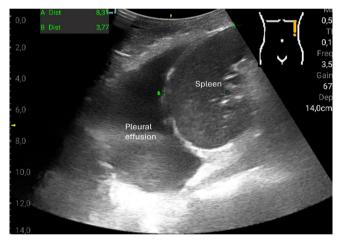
Sonographic image of a large left-sided pleural effusion captured with the Youkey Q7. The patient received therapeutic pleural drainage
